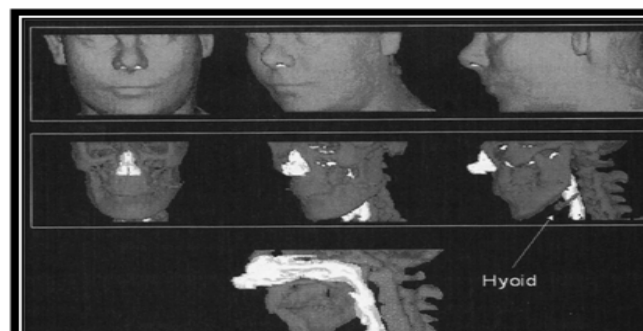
CT scan Showing Airway.
